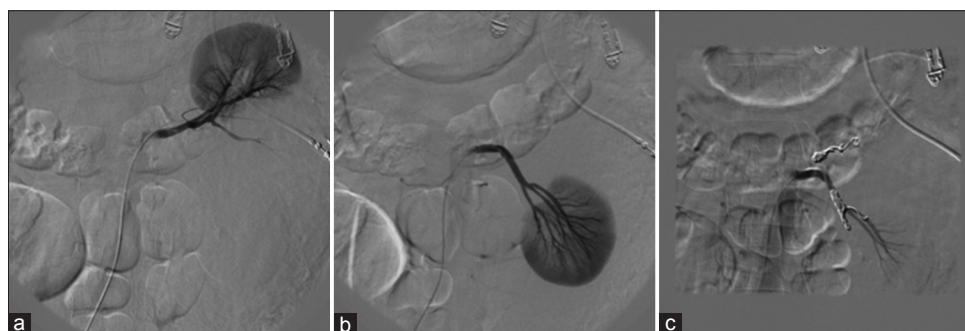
Embolization and computed tomography showing selective catheterization of left renal upper arteries (a) and left renal lower arteries (b), and inserted coils (c)
